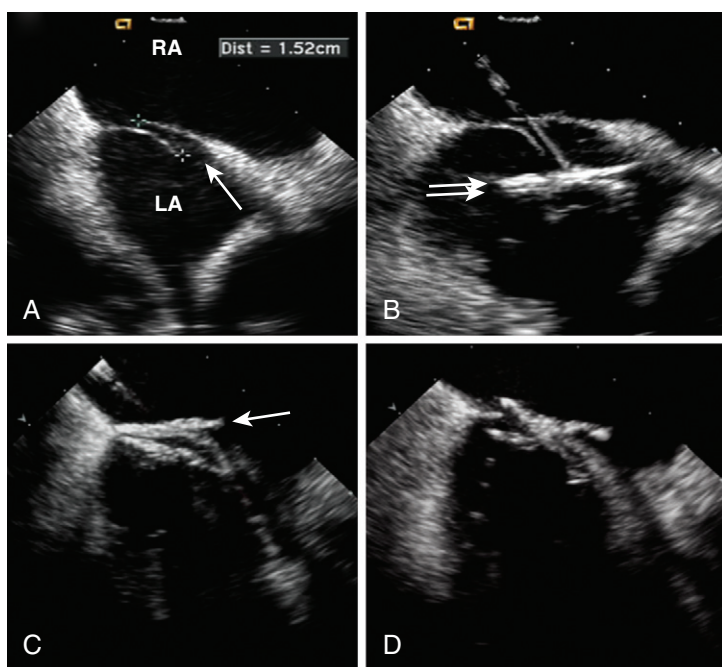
Intracardiac echocardiography in a patient with patent foramen ovale (PFO). A, Septal view, demonstrating the PFO (*arrow*) and the thin septum primum. B, The left atrial disc (*arrow*) deployed in the left atrium. C, The right atrial disc (*arrow*) deployed in the right atrium. D, The device released, demonstrating good position.
